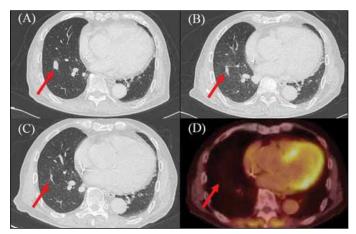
Computed tomography of the lung after single-agent carboplatin chemotherapy showed a therapeutic effect as evidenced by the maximum dimensions of the lesion. A: After three cycles. B: After five cycles. C: After eight cycles. D: 2-18Fluorodeoxy-D-glucose positron emission tomography (FDG-PET) of the lung 6 months after 13 cycles of chemotherapy.
